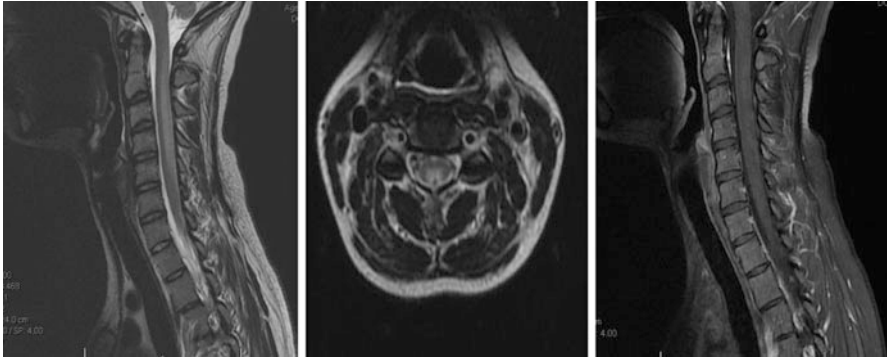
MRI imaging for case Example 3. *Left* T2-weighted sagittal images, *middle* axial T2 images, and *right* sagittal T1-weighted postcontrast images. The images show abnormal signal predominantly in the dorsal columns and the lesions are not contrast enhancing. Courtesy: Pearse Morris, MD
